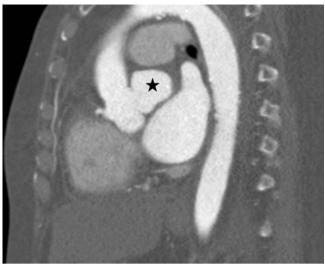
Sagittal contrast-enhanced CT of a saccular (left) sinus of Valsalva aneurysm
